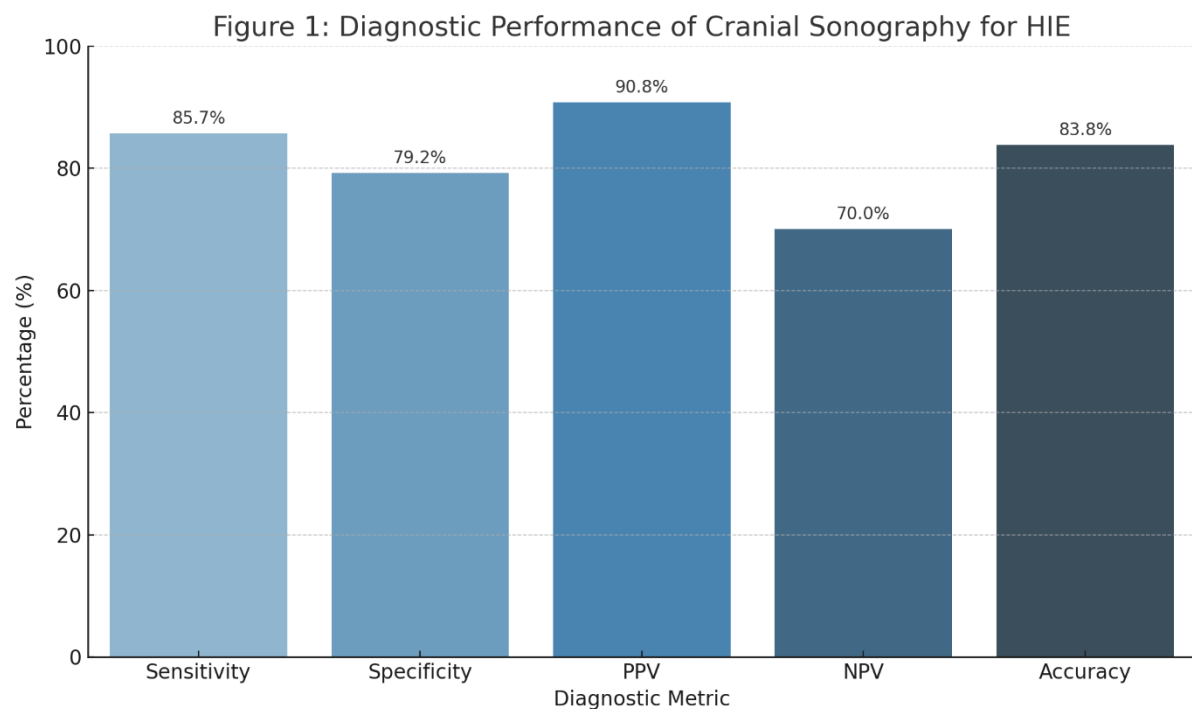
Diagnostic performance metrics of cranial sonography for the detection of hypoxic ischemic encephalopathy (HIE) in premature neonates
